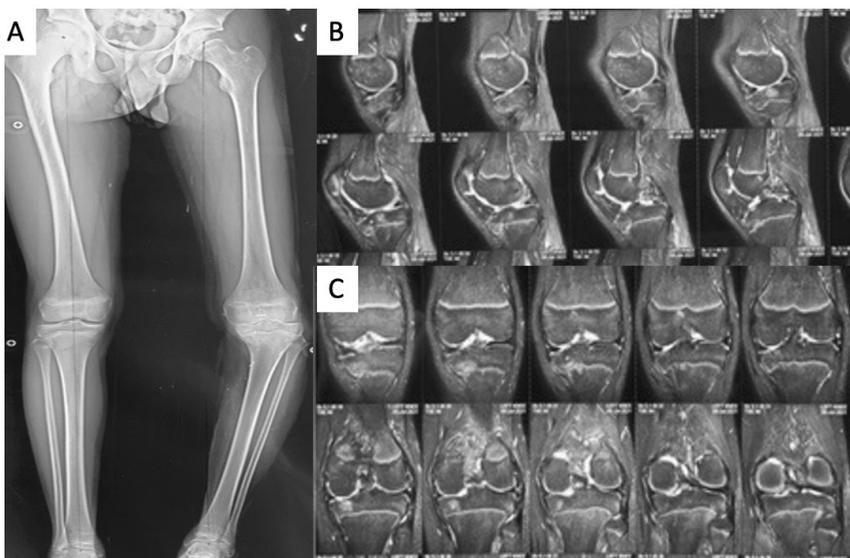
A: Scannogram showing the varus alignment of left knee. B & C: Pre-operative MRI confirming the diagnosis of proximal medial tibial physis injury and PCL injury
